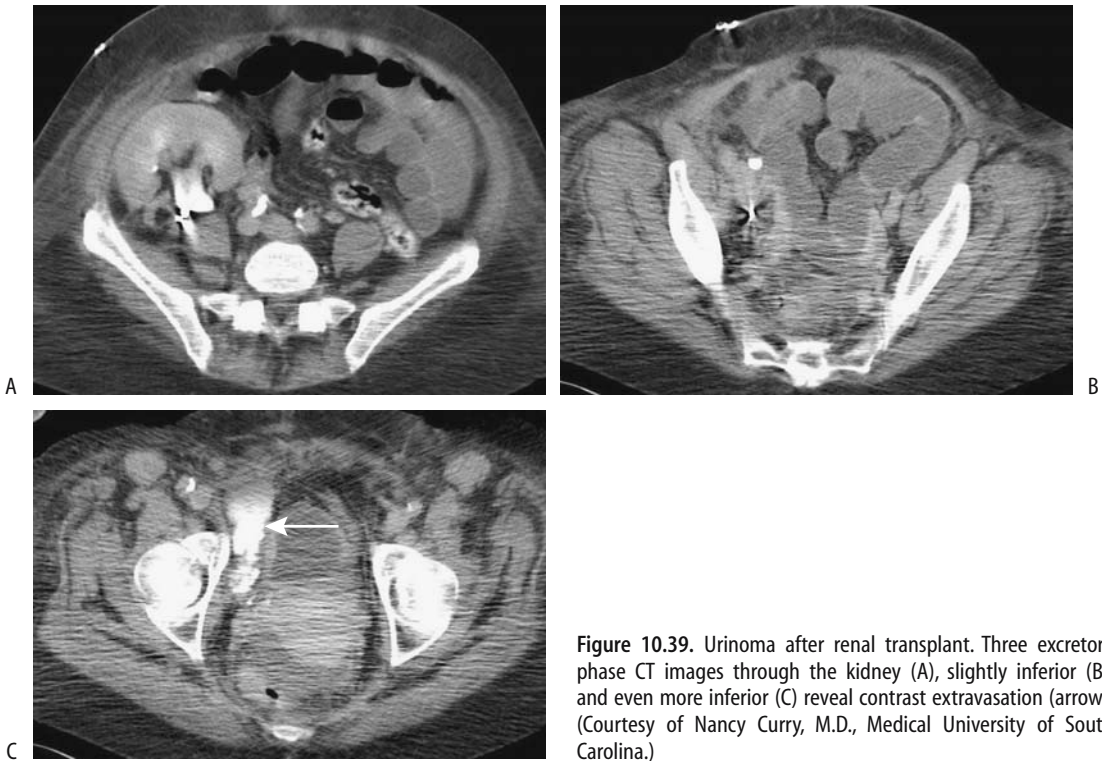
Urinoma after renal transplant. Three excretory phase CT images through the kidney (A), slightly inferior (B), and even more inferior (C) reveal contrast extravasation (arrow). (Courtesy of Nancy Curry, M.D., Medical University of South Carolina.)
